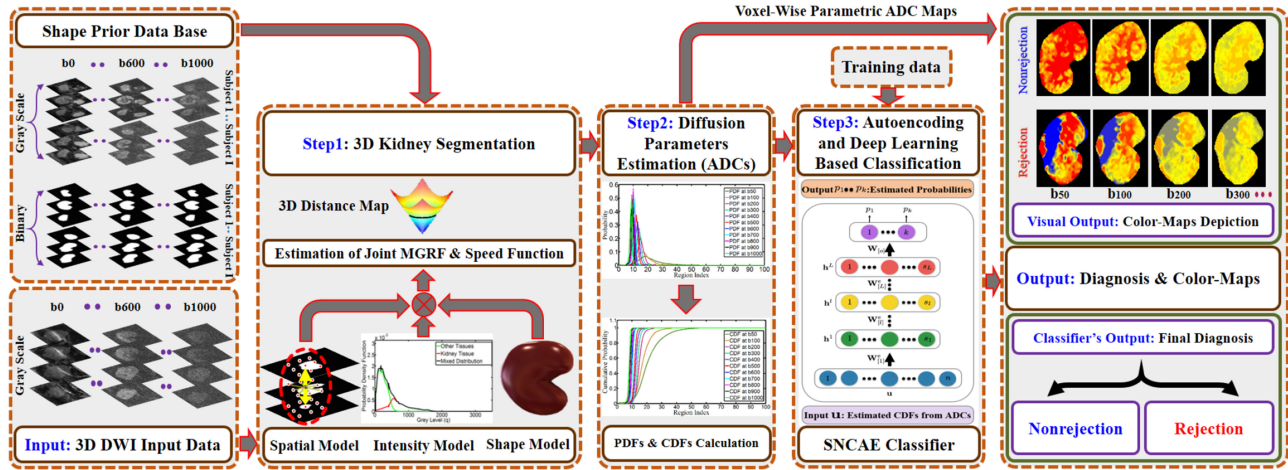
The presented CAD system for detecting renal rejection from (3D + b -value) DW-MRI.
